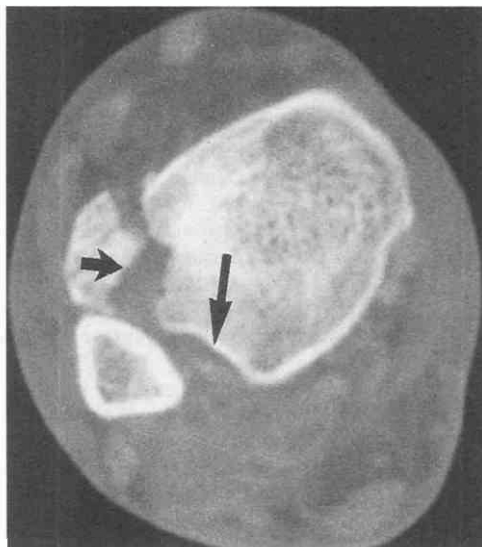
Axial CT image of the lower leg demonstrates disruption of the distal tibia fibular articulation with the fibular subluxated anteriorly out of its sulcus (*large arrow*). A large avulsion fragment is seen at the tibial insertion of the anterior tibiofibular ligament (*small arrow*). This avulsion represents an adult Tillaux fracture.
